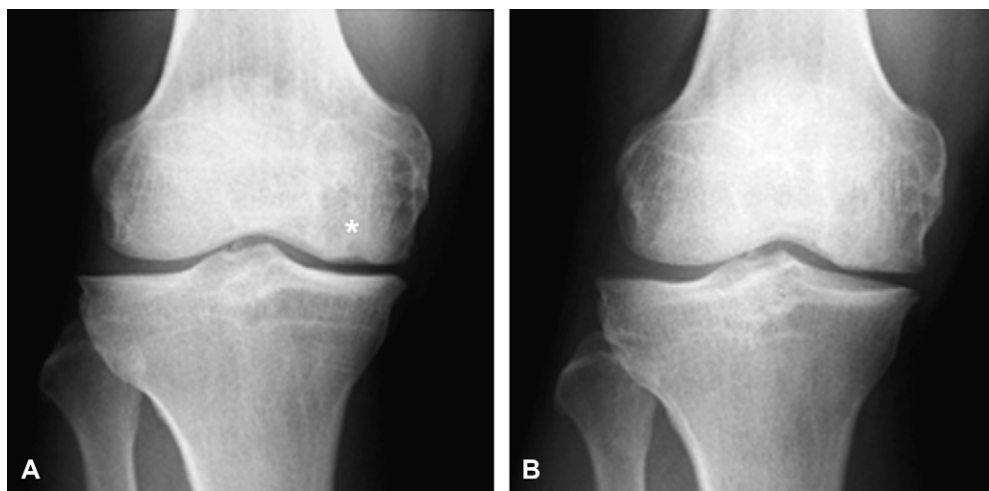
(A) Anterior–posterior X-radiographic view of the weight-bearing knee before surgery. The image reveals a radiolucent area (\*) within the medial femoral condyle. (B) Anterior–posterior X-radiographic view of the weight-bearing knee 1 year after surgery. No radiolucent area is now apparent within the medial femoral condyle.
